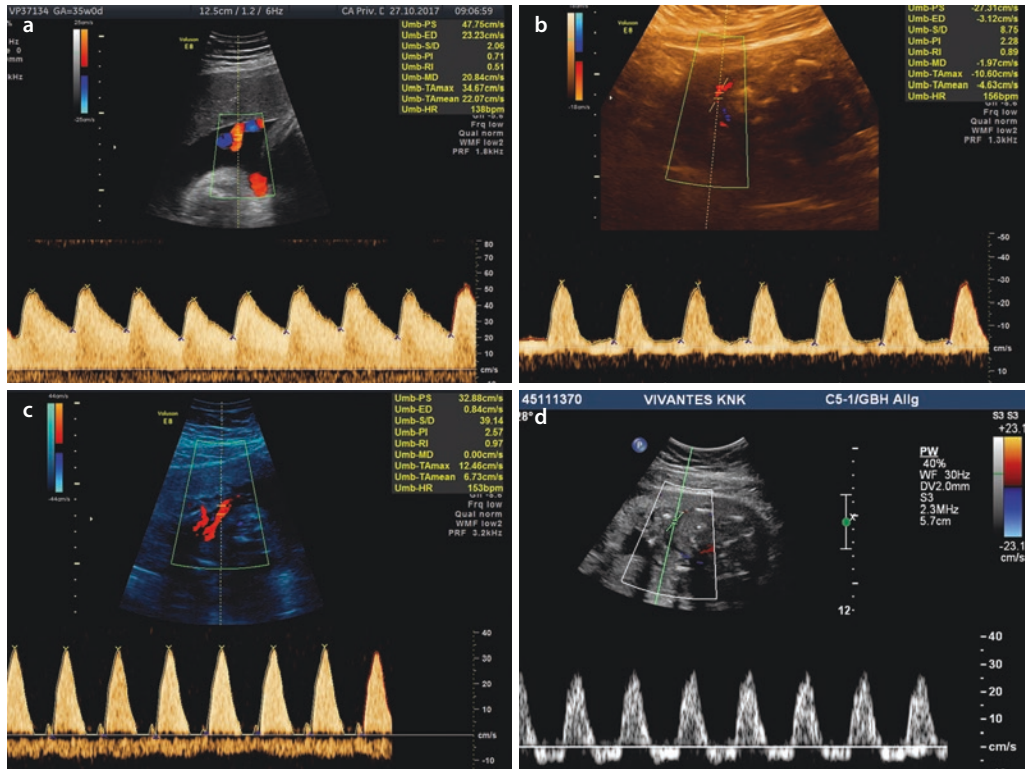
a–d Doppler sonography of the umbilical arteries. Normal flow pattern of the umbilical artery a Doppler sonographic changes in the blood flow of the umbilical artery during fetal growth
